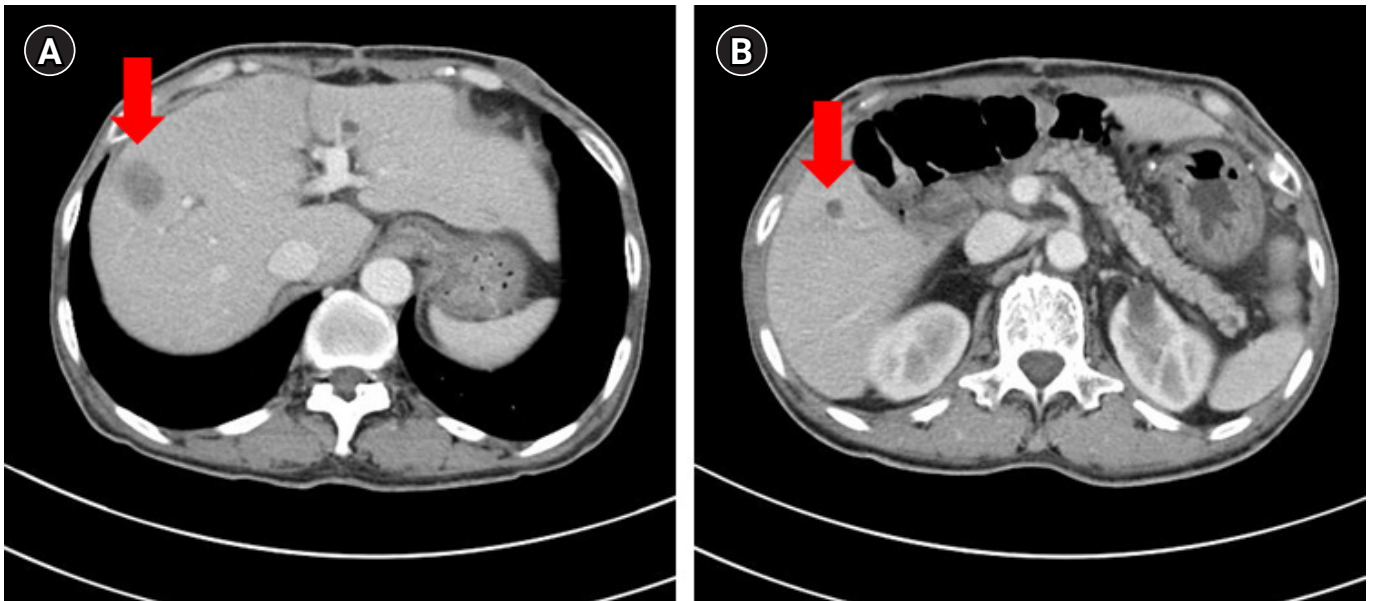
Computed tomographic findings of two liver metastases (arrow). (A) A 2.4-cm metastatic mass at liver segment 8. (B) An 0.6-cm metastatic nodule at liver segment 5.
